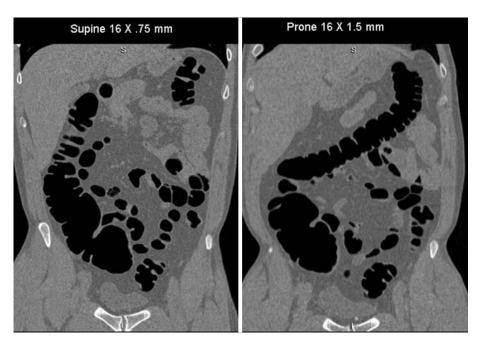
Coronal reformatted image from CT colonography data sets shows supine acquisition (left) and prone acquisition (right) in same patient. CTC data obtained in supine positions was obtained with 16×75 mm slices and the prone acquisition with 16×1.5 mm slices. Obviously there is better Z-axis resolution on the supine data set. The CTDI was 14% higher for the supine acquisition
